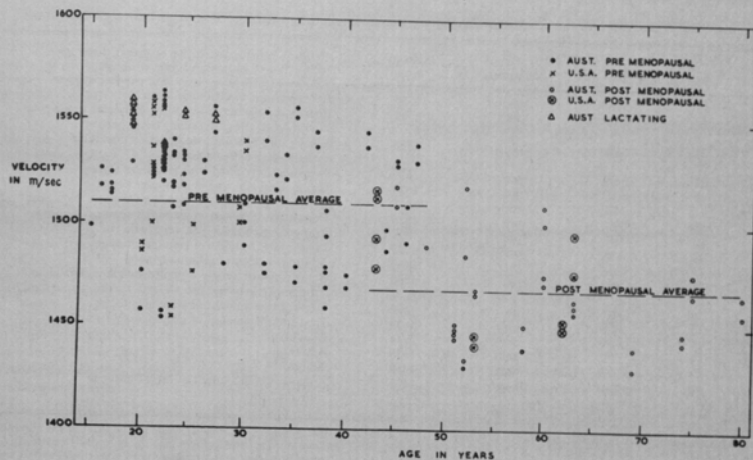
Average velocity of ultrasound in normal subjects in the U.S. and in Australia.
